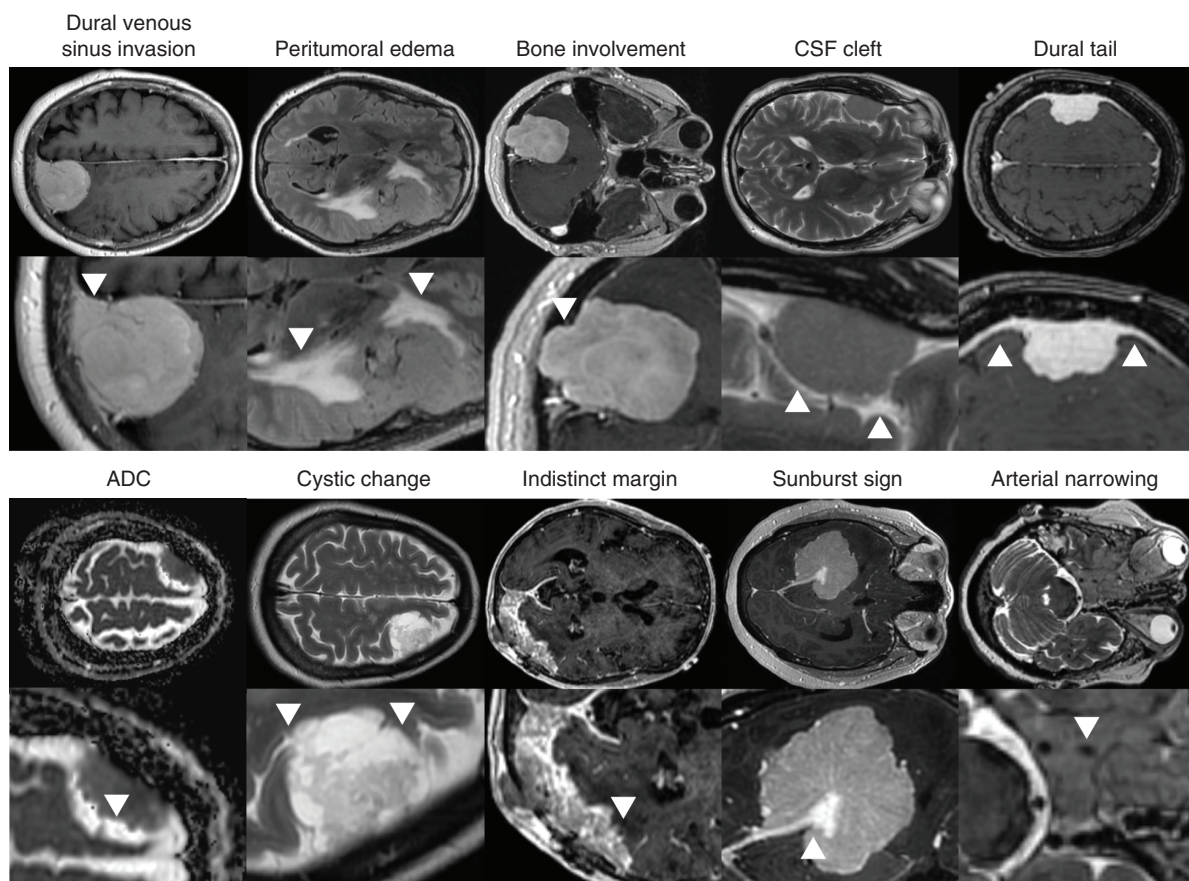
Radiologic Features of Meningiomas. Figure reproduced and used with permission from Morin, Chen et al.⁴⁸ Examples of radiologic features annotated on preoperative MRIs, such as axial T1 post-contrast image showing a dural tail (arrows) from a right frontal meningioma, axial T2 image showing a CSF cleft sign (arrows) from a right temporal meningioma, axial T1 post-contrast image showing bony involvement (arrow) of the right occipital bone from a right cerebellar meningioma, axial FLAIR image showing peritumoral edema (arrows) from a left frontal meningioma, axial T1 post-contrast image showing dural venous sinus invasion (arrow) from a left posterior parasagittal meningioma, axial T2 image showing narrowing of the right internal carotid artery flow void (arrow) from a multi-compartmental right skull base meningioma, axial T1 post-contrast image showing a “sunburst” sign (arrow) in a right tentorial meningioma, axial T1 post-contrast image showing an indistinct tumor margin with brain parenchyma (arrow) from a left occipital meningioma, axial T2 image showing cystic changes (arrows) in a left frontal meningioma, and an ADC map showing signal hypointensity (arrow) in a right frontal meningioma. Of these features, venous sinus involvement, absence of CSF cleft, ADC hypointensity, peri-tumoral edema, and indistinct margins were associated with increased risk of local failure.⁴⁸
